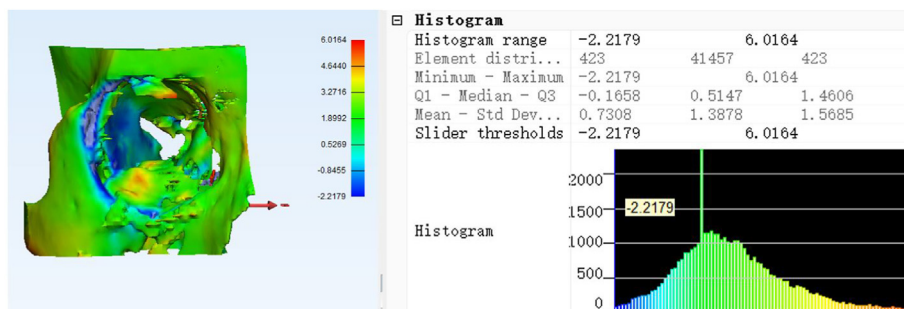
In a fracture of the zygoma-orbit complex, data from virtual planning and postoperative CT data were superimposed in 3-Matic Research 11.0, and the difference in distance was also calculated.
